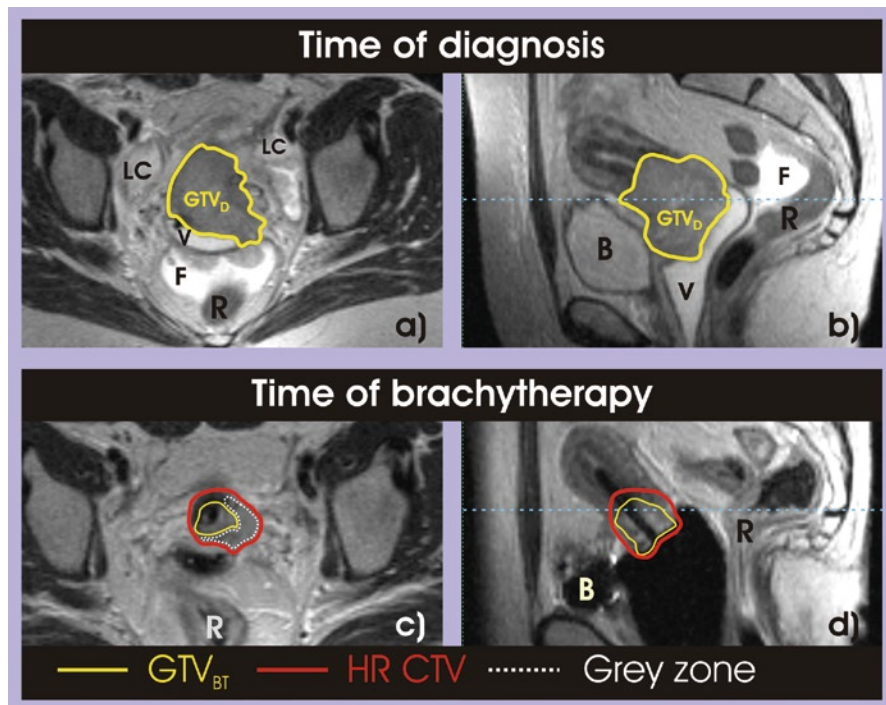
MRI scans of a patient with FIGO IIB cervical cancer at time of diagnosis ((a) – axial plane, (b) – sagittal plane) and at time of brachytherapy ((c) – axial plane, (d) – sagittal plane). Tumor at time of diagnosis (GTV_D), which replaces the uterine cervix (a, b) and invades the left parametrium (a), is depicted as a homogeneous intermediate signal intensity mass. At the time of brachytherapy, HR CTV consists of high signal intensity residual tumor (GTV_{BT}), intermediate signal intensity “grey zones” and low signal intensity cervical tissue (c, d). Dotted blue line on sagittal images represents the level at which the correspondent axial scan was obtained (LC, lymphocyst after laparoscopic lymph node staging; F, free fluid in the pouch of Douglas; V, vagina contrasted with ultrasound gel; B, bladder; R, rectum)
